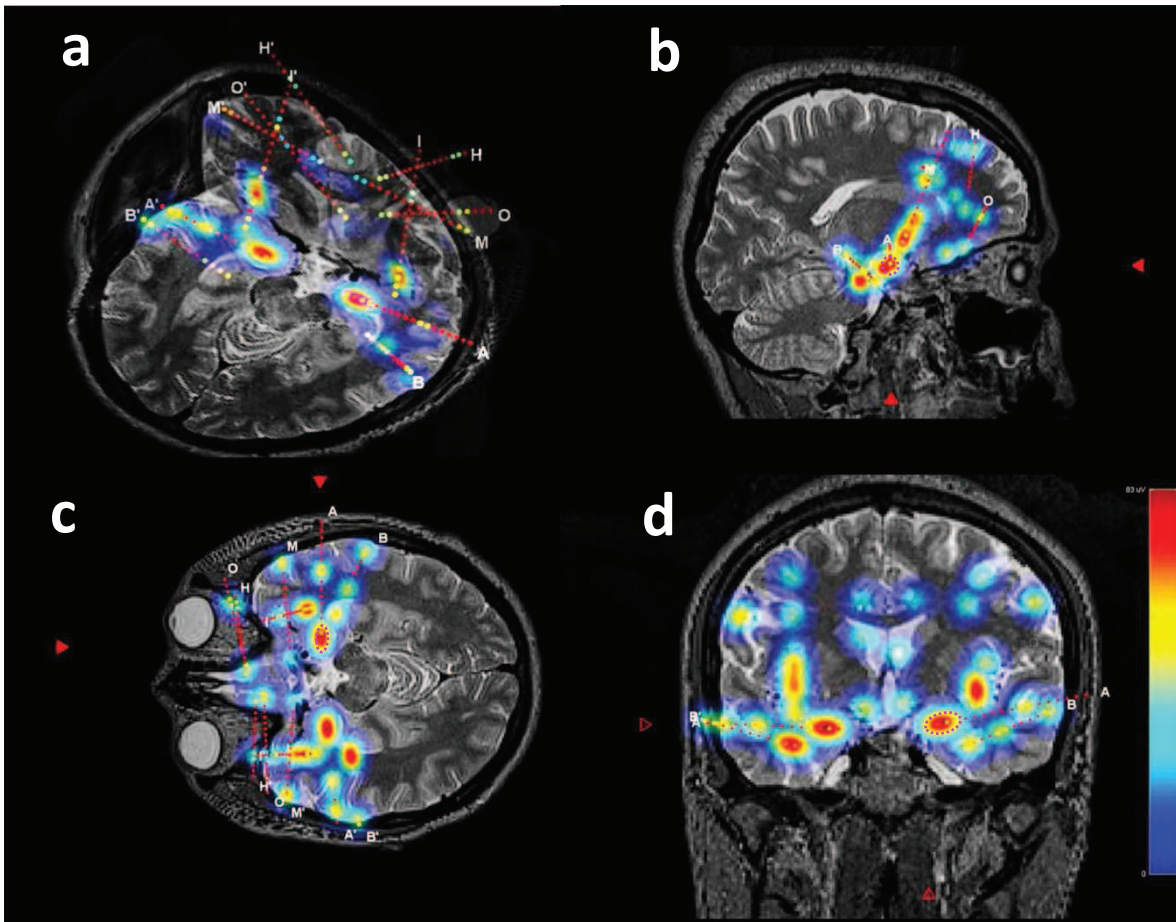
3D inbound activation maps showing mean evoked responses, by location of recording, regardless of the stimulation location, for patient 10. a) 3-D view of the maps, blended with MRI scans; b,c,d) MIP projections of the excitability on sagittal, axial and coronal MRI views. SOZ contacts, marked using magenta circles.
